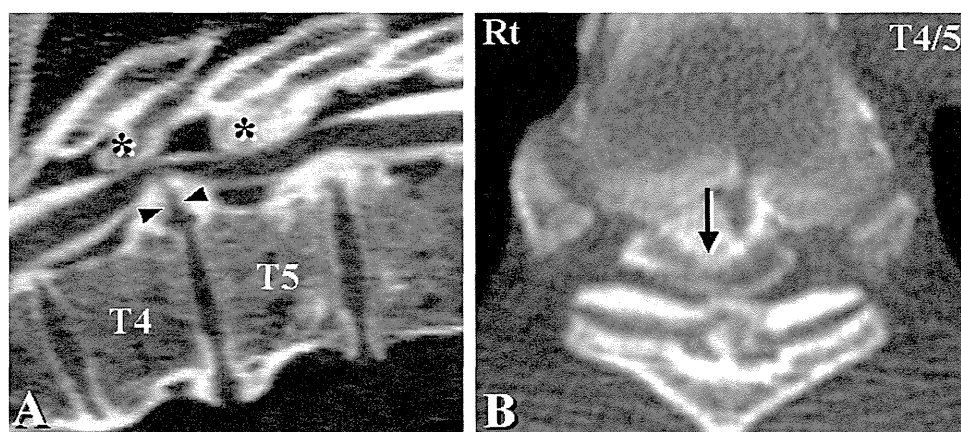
Preoperative midsagittal (A) and axial (B) reconstruction images from a CT myelogram showing impingement of the spinal cord anteriorly by a beak-type ossification of the posterior longitudinal ligament (OPLL) (A, B, arrow) and posteriorly by ossification of the ligamentum flavum (A, asterisks) at T4/5. The mid-portion of the beak-type OPLL contains a non-ossified area (A, arrowheads).
